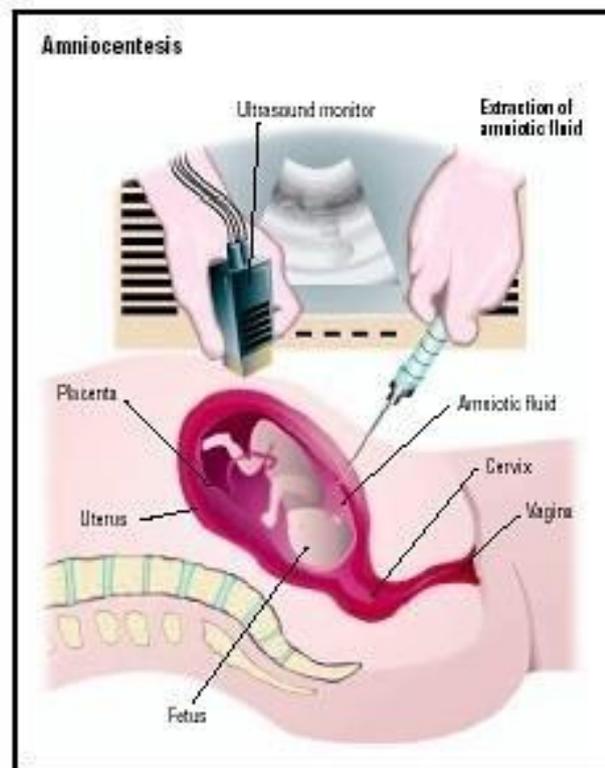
To perform amniocentesis, a physician uses an ultrasound monitor to visualize the foetus while inserting a syringe to extract amniotic fluid for analysis.
